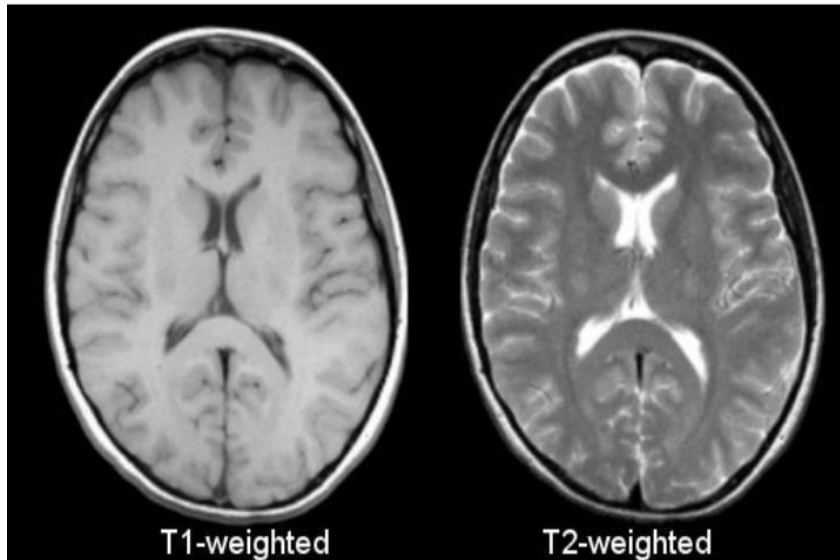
T1 and T2-weighted images (Preston 2006)
